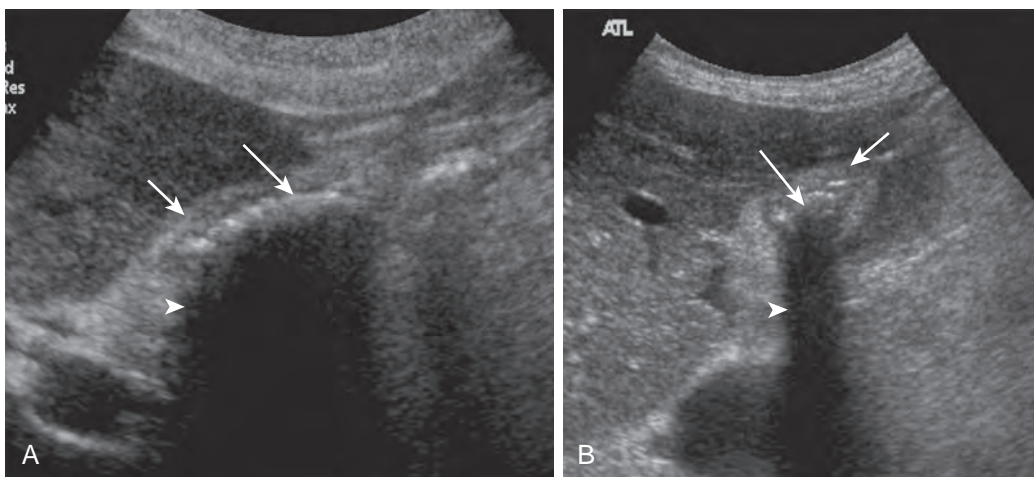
Wall-echo-shadow sign on ultrasound. Multiple gallstones are present within a contracted gallbladder. Sagittal (A) and transverse (B) views. Short arrow points to gallbladder wall that appears as an echogenic arc. Long arrow points to gallstones that appear as bright echoes. The arrowhead points to posterior acoustic shadowing.
